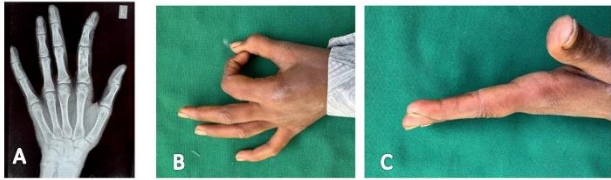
(A) one-year postoperative radiograph showing no recurrence and maintained cortical structure, (B) clinical image demonstrating improved finger flexion and (C) clinical image demonstrating improved finger extension and functional recovery.
